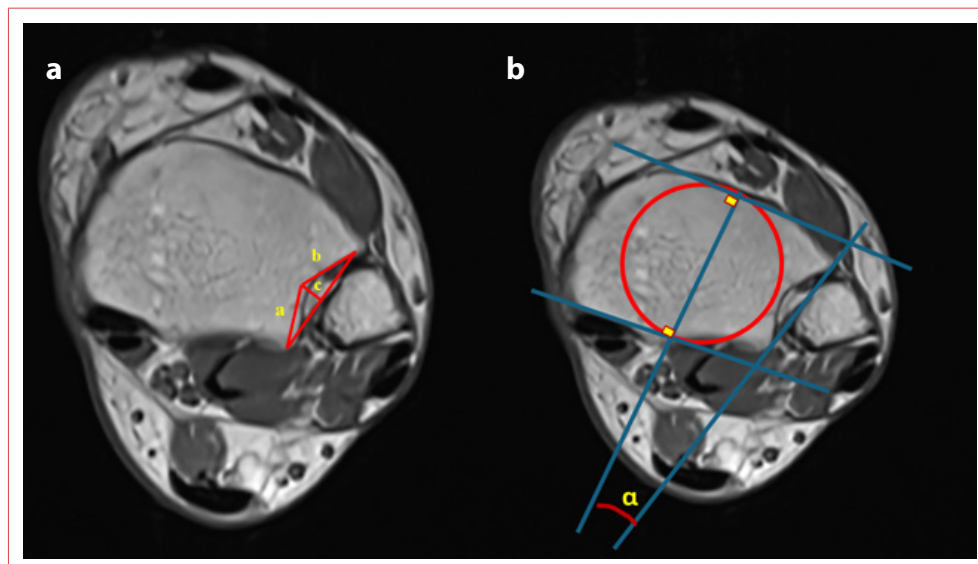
Magnetic resonance imaging-based measurements of fibular notch morphology. (a) Measurement of the anterior and posterior tubercle lengths and the anterior-posterior tubercle angle (APFA). a=Represents the posterior tubercle length, b=The anterior tubercle length, and c=The APFA. (b) Measurement of fibular notch version, with α=Representing the version angle.
